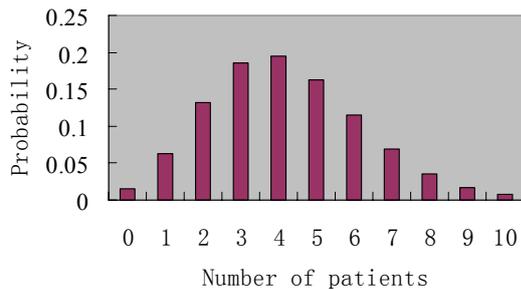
A poisson distribution of patients arriving in B-ultrasound examination
